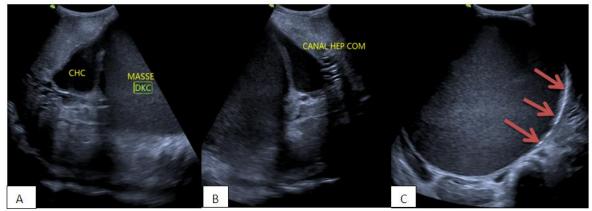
Abdominal ultrasonography (US): Show a largeCystic dilation of common bile duct (A and B) with homogeneous hypoechoic content with (C) calcification of the wall (red arrow).
